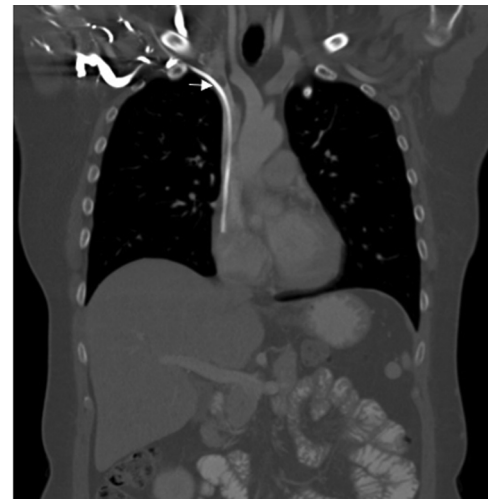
CT scan with evidence of portacath-associated thrombosis of the *V. brachiocephalica dextra* (arrow).
